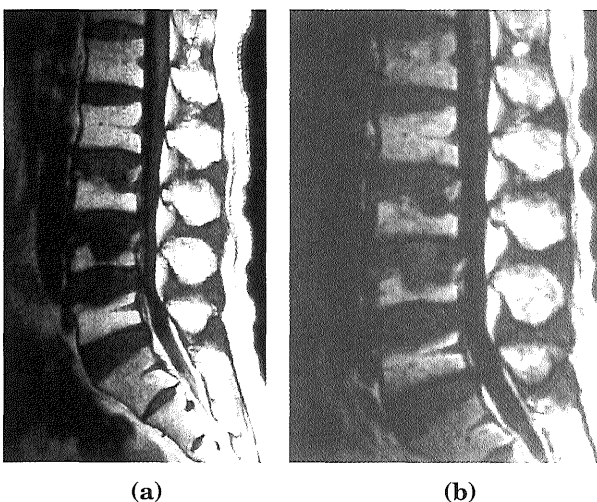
MRI 10 (a) and 20 (b) months after radiotherapy showed no progression of bone metastases.
